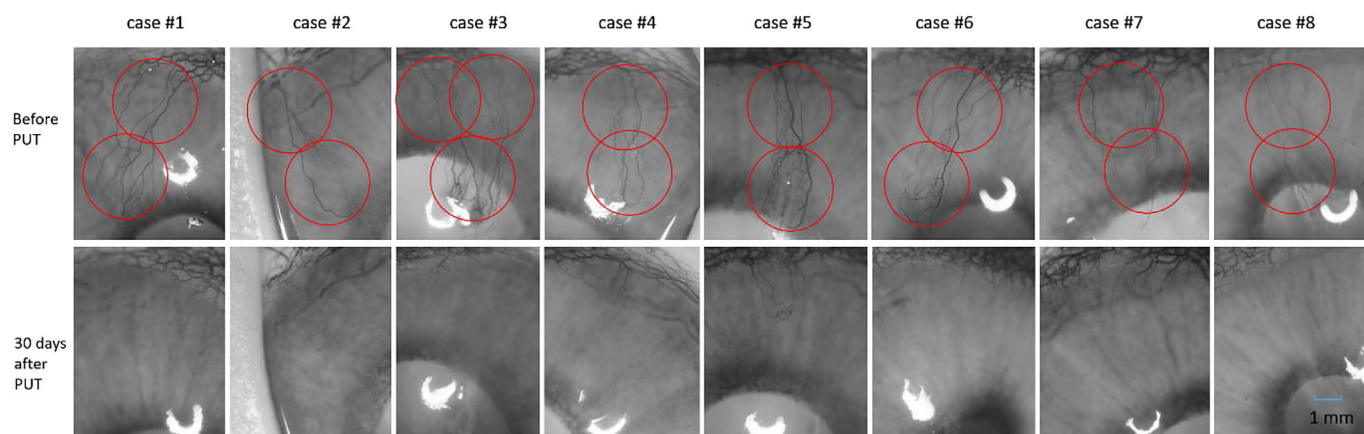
Red-free photographs of rabbit CNV before and at 30 days after PUT treatment (eight cases). The red circles show the treatment areas, which have a diameter of 3 mm. A significant reduction in CNV at 30 days after PUT treatment can be observed. The applied ultrasound pressure was 0.43 MPa at 0.5 MHz, the applied laser fluence was 27 mJ/cm² at 1064 nm, and the treatment duration in each treatment area was 10 minutes.
